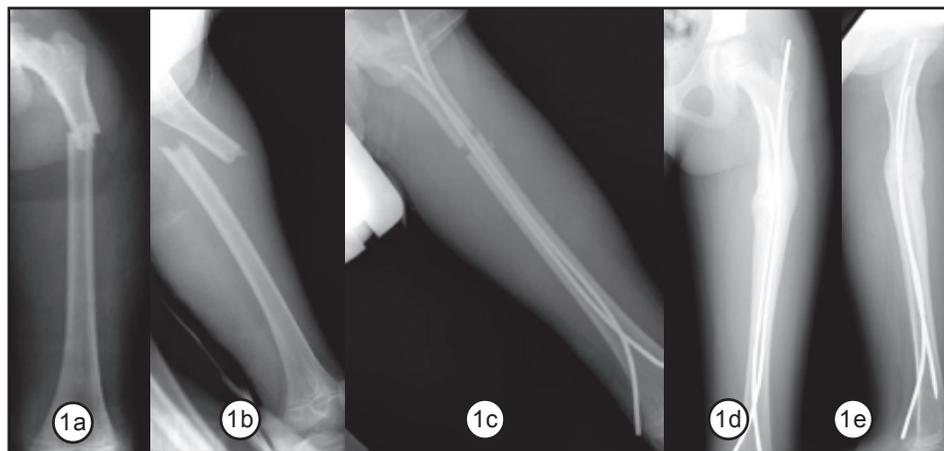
Pre-operative X-rays; Figure 1c : Immediate post-operative X-ray; Figure 1d & 1e : At 6 months post-operative X-rays showing good union
